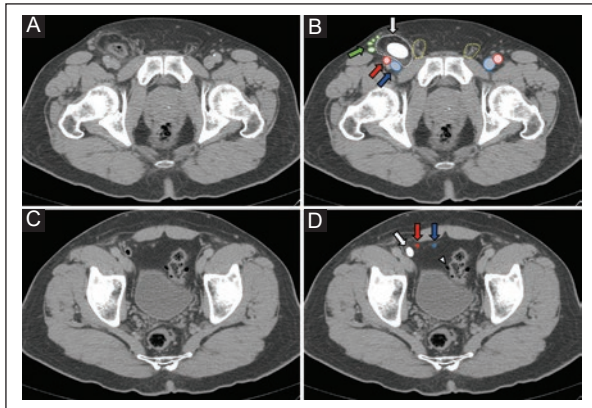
Simple and venous delay phase abdominopelvic CT scan of a 59-year-old male patient. A-B: venous delay phase in the axial plane at the level of the pubic symphysis, a right femoral hernia is observed (white arrow) with the presence of a hernia sac (white dotted line) and Meckel's diverticulum content (white oval), in association with reactive nodes (green arrow and circles) and effacement of the fatty planes, lateral to the inguinal canal (yellow dotted line) and medial to the common femoral artery and vein (red, blue arrow and circle, respectively). C-D: in the axial plane at the level of the acetabular roof, Meckel's diverticulum (white arrow and circle) is seen lateral and inferior to the epigastric artery and vein (red and blue arrow and circle respectively); sigmoid diverticulosis is shown as an incidental finding (white arrowhead).
